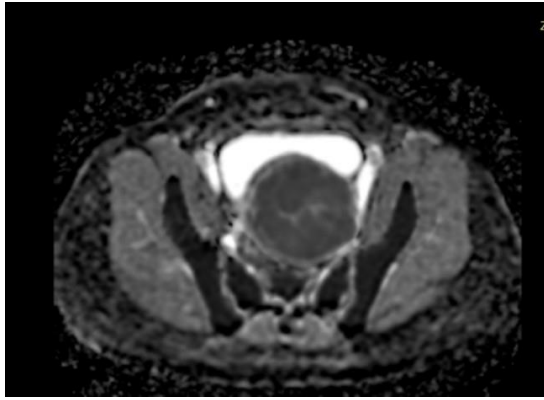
MRI revealed that the ADC value of the tumor was low
